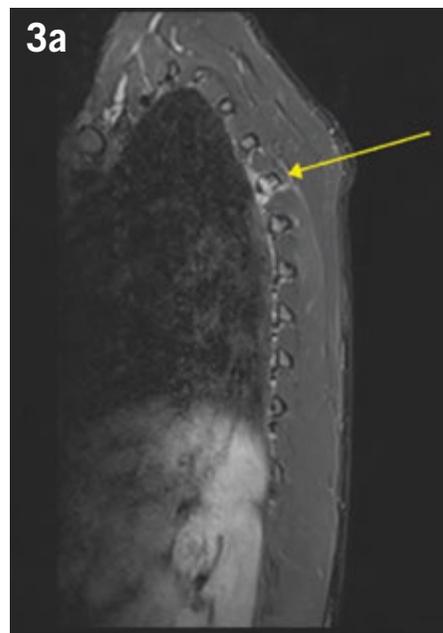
27 year old professional golfer with acute on chronic left sided chest wall pain preventing competitive golf. MRI demonstrates bone marrow oedema (b) with low T1 signal (a) in keeping with established bone stress. CT of the same player (c) showed normal appearances of the ribs in keeping with bone stress without structural failure (fracture).
